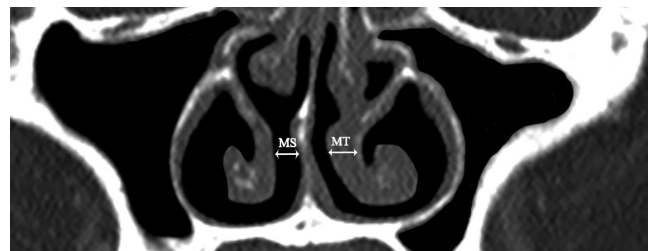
Anatomical evaluation of the nasal cavity by computed tomography. The unit for mucosal thickness (MT) and medial space (MS) is millimeters.
